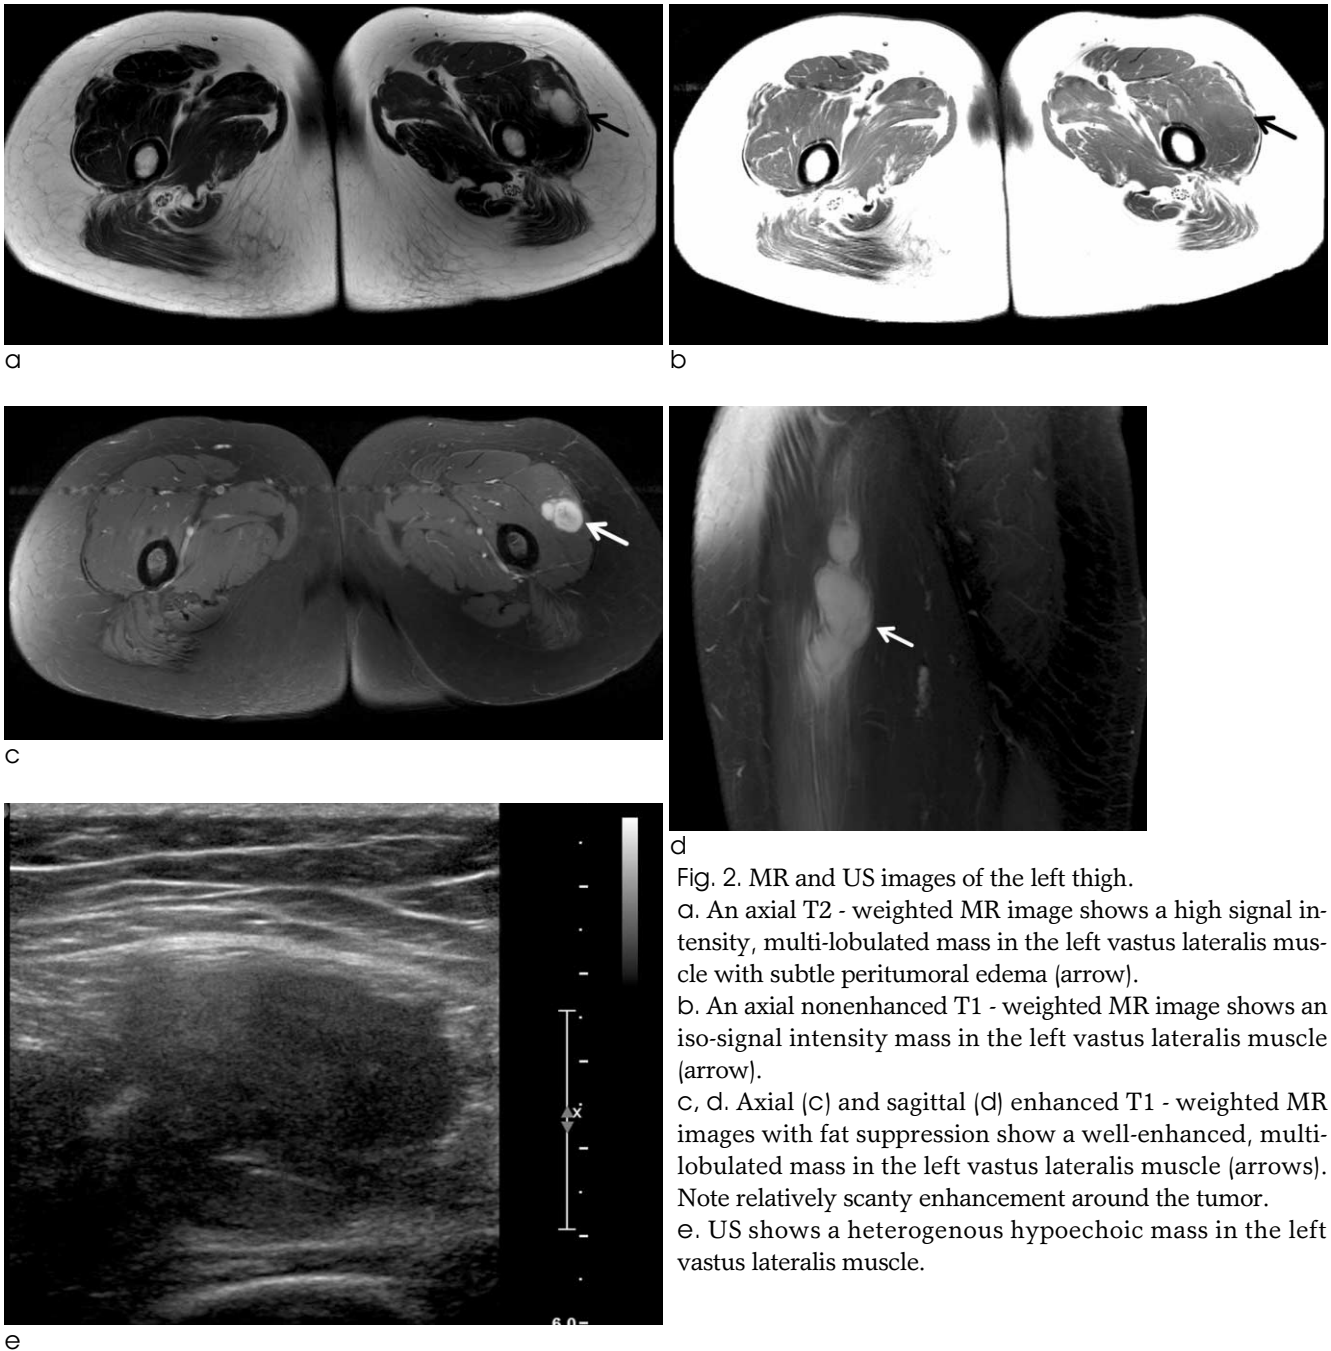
MR and US images of the left thigh. a. An axial T2 - weighted MR image shows a high signal intensity, multi-lobulated mass in the left vastus lateralis muscle with subtle peritumoral edema (arrow). b. An axial nonenhanced T1 - weighted MR image shows an iso-signal intensity mass in the left vastus lateralis muscle (arrow). c, d. Axial (c) and sagittal (d) enhanced T1 - weighted MR images with fat suppression show a well-enhanced, multi-lobulated mass in the left vastus lateralis muscle (arrows). Note relatively scanty enhancement around the tumor. e. US shows a heterogenous hypoechoic mass in the left vastus lateralis muscle.
